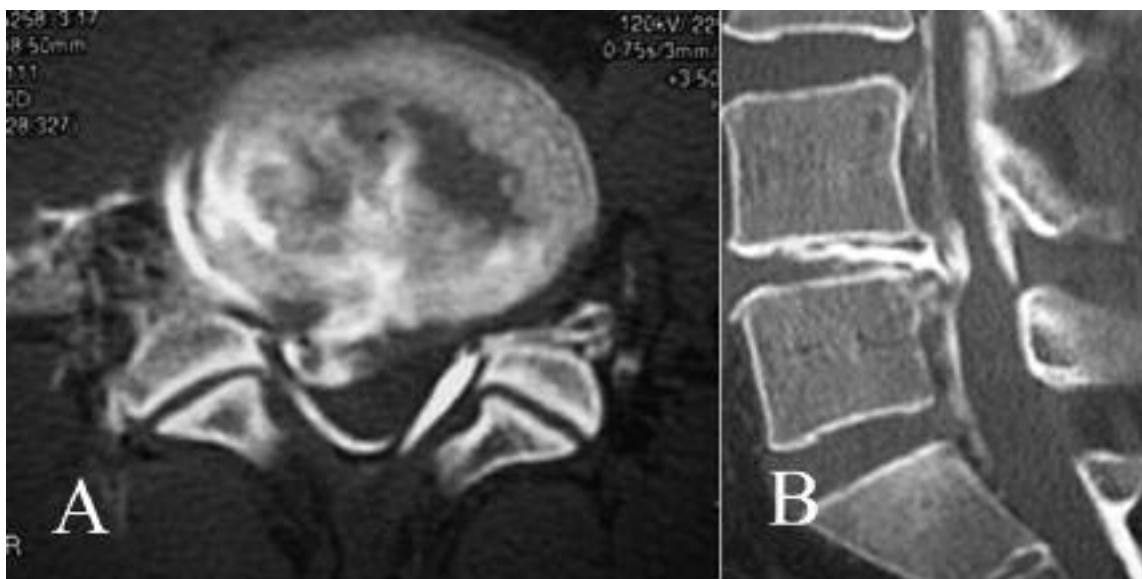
CT after discography reveals leakage of contrast medium into the epidural space but not the intradural space
